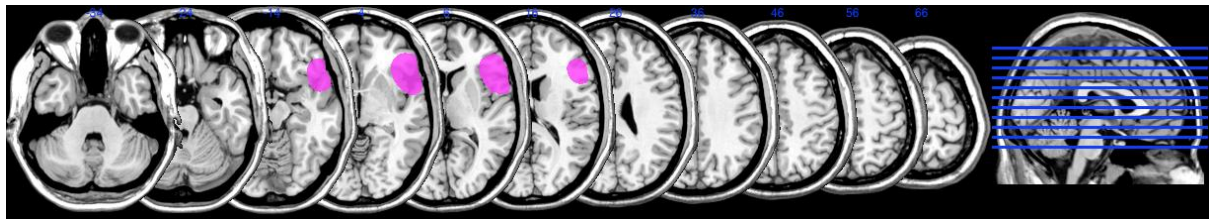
MRI scan of patient BS
